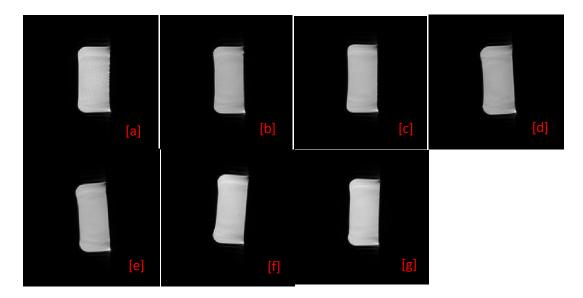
MR images from Vibrant sagittal data with a) 10, b) 20, c) 30, d) 45, e) 60, f) 75 and g) 90 pores per inch (PPI) foam
